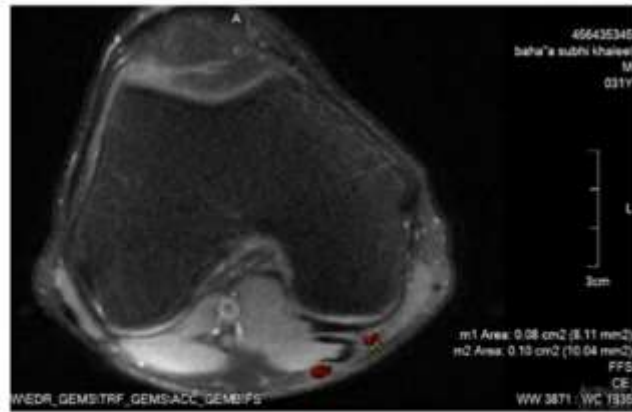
axial MRI at level of maximum diameter of patella.
